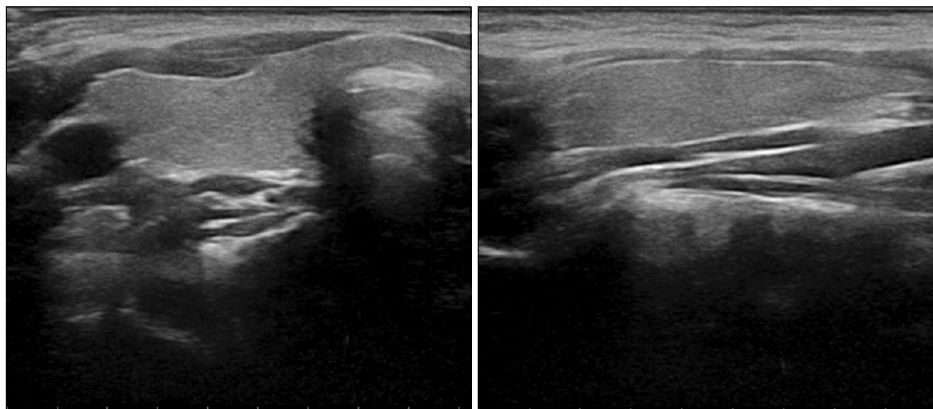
Follow-up ultrasonography showed resolution of the hypoechoic nodule in the right lobe of the thyroid gland.
